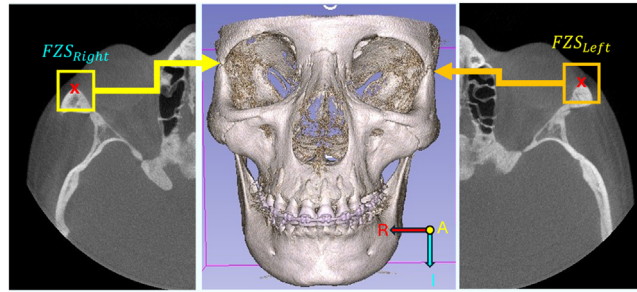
Example of FZS location. Left - Right FZS located on the left half of the axial projection. Center - Reconstruction of the CBCT volume using the RAI reference system. Right - Left FZS located on the right half of the axial projection.
